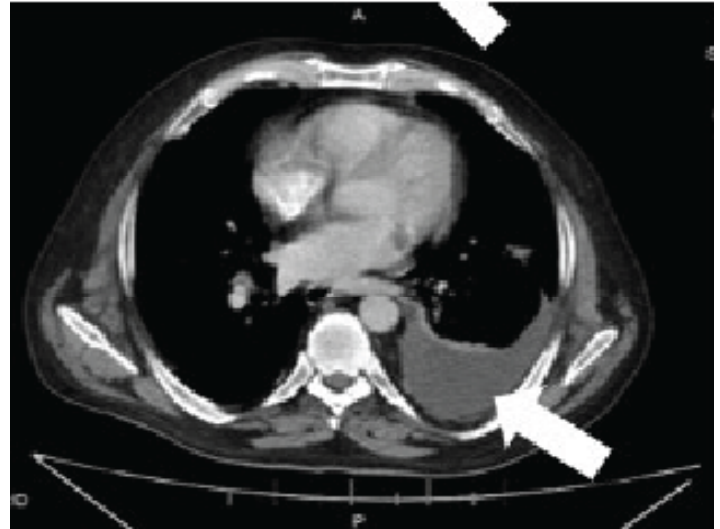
Computed tomography abdomen and pelvis showing a pleural effusion (arrow) of the left lung base with atelectasis.
